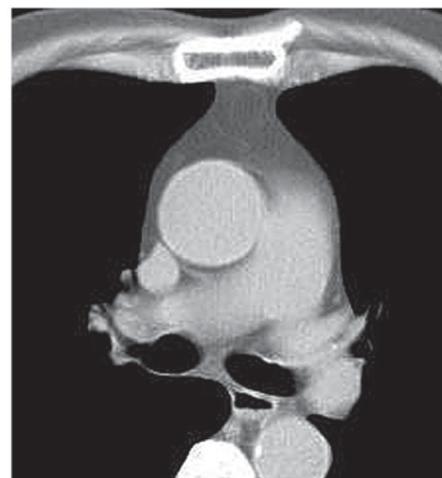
Unenhanced CT image of a male myasthenia gravis patient (age, 72 years) with normal thymus. The thymus is quadrilateral in shape and homogeneous regarding CT attenuation. CT, computed tomography.
